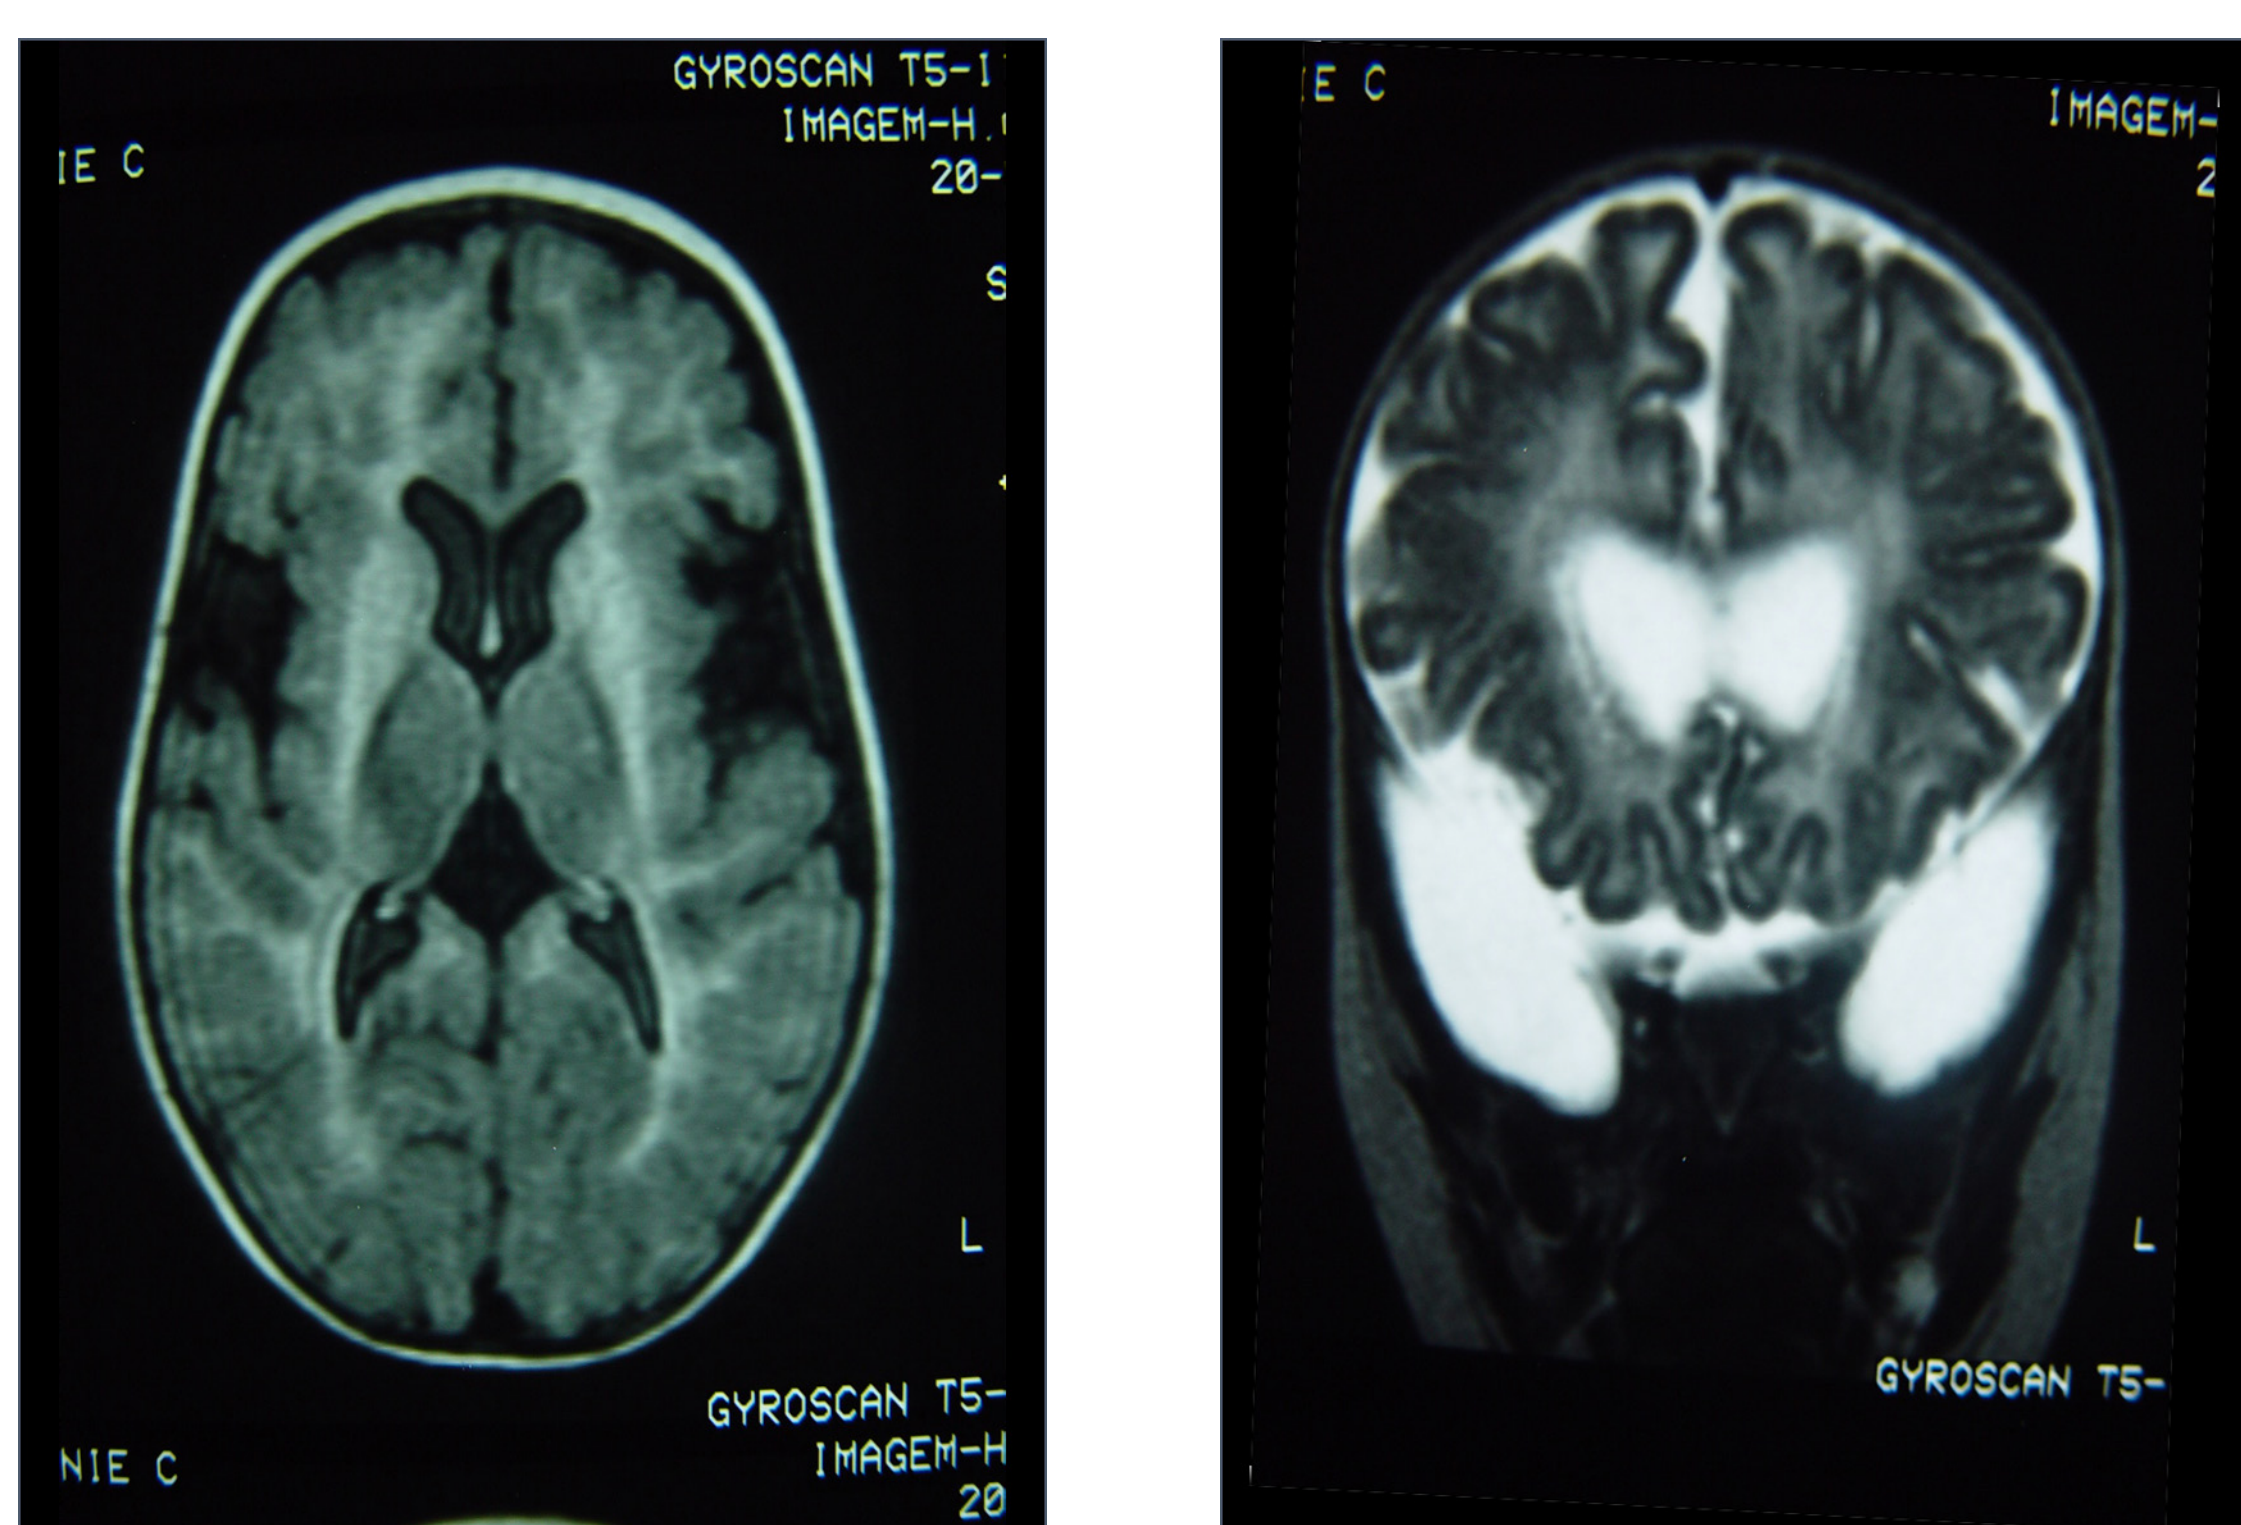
Brain magnetic resonance imaging of an infant with glutaric aciduria type I at 10 months of age.
